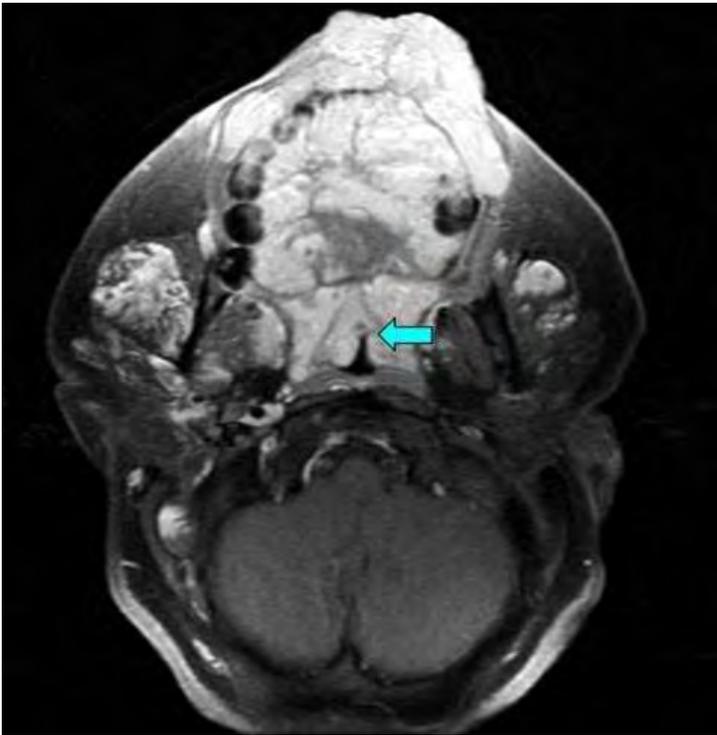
Axial T1 post contrast MRI head demonstrating vascular malformation of the lower lip, tongue, and oropharyngeal stenosis. Narrowest point of oropharyngeal stenosis measuring 10 mm x 3 mm (blue arrow).
